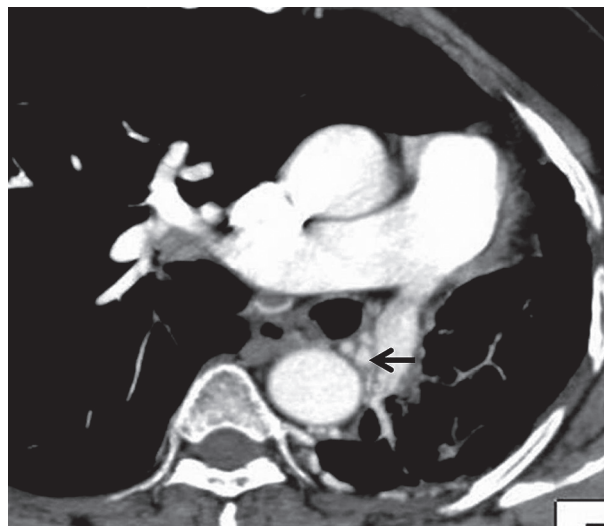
Axial post-contrast chest computed tomography image mediastinal window showing left-sided volume loss due to collapse of the left lung. There is hypertrophy of the bronchial arteries (black arrow)
